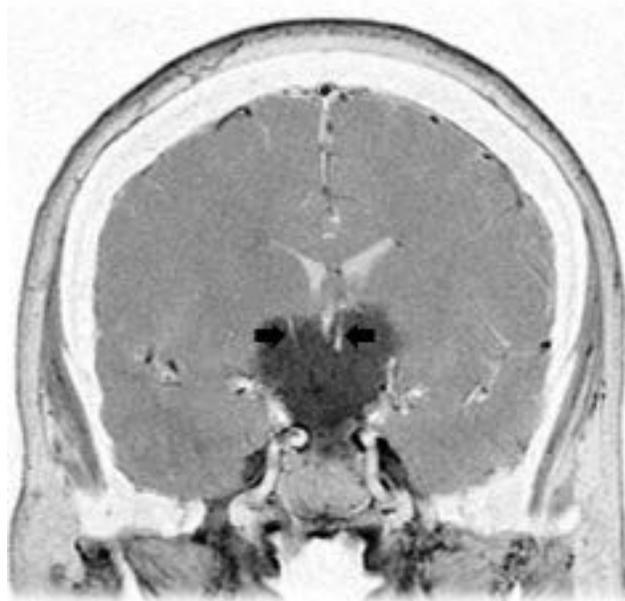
Coronal postcontrast T1-weighted magnetic resonance imaging identifies encasement of the A2 segments of the anterior cerebral arteries (*arrows*). Property of the Department of Neurosurgery, The University of Texas M.D. Anderson Cancer Center. Used with permission.
